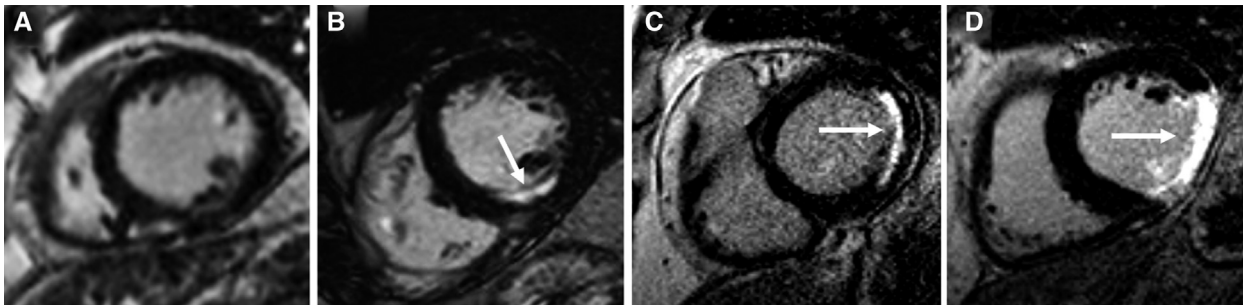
Cardiovascular magnetic resonance imaging assessment of myocardial viability and infarction using late gadolinium enhancement (LGE). (A) LGE image in a mid short-axis location showing homogenous signal in all segments with no evidence of myocardial infarction. (B) LGE image in short-axis orientation showing subendocardial infarction (25–50% transmural extent) in the inferior wall. (C) LGE image in short-axis orientation showing myocardial infarction involving 50–75% of wall thickness in the lateral wall. (D) LGE image in short-axis orientation showing transmural infarction in the lateral wall (*white arrow*).
